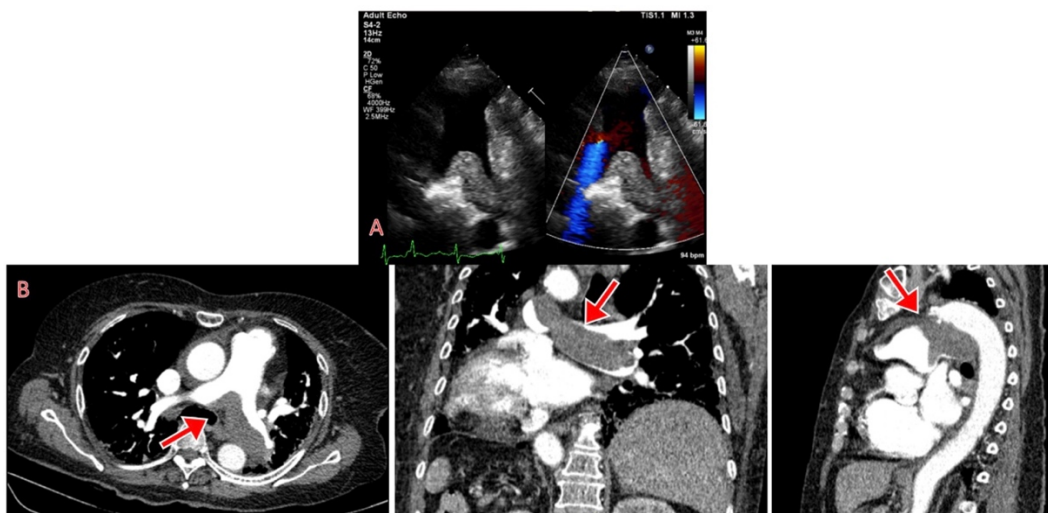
(A) Thrombus seen in main pulmonary artery and both branches on transthoracal echocardiography;
